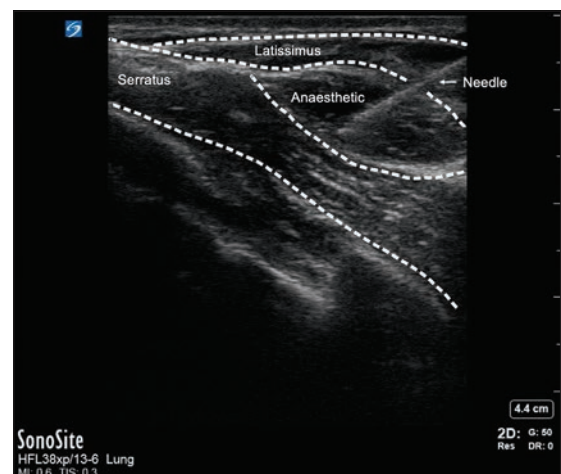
Anaesthetic deposition visualised by ultrasound. An echogenic needle is inserted in-plane to the ultrasound probe and into the superficial serratus anterior fascial plane. Bupivacaine is deposited, creating a separation between the serratus anterior and the latissimus dorsi.
